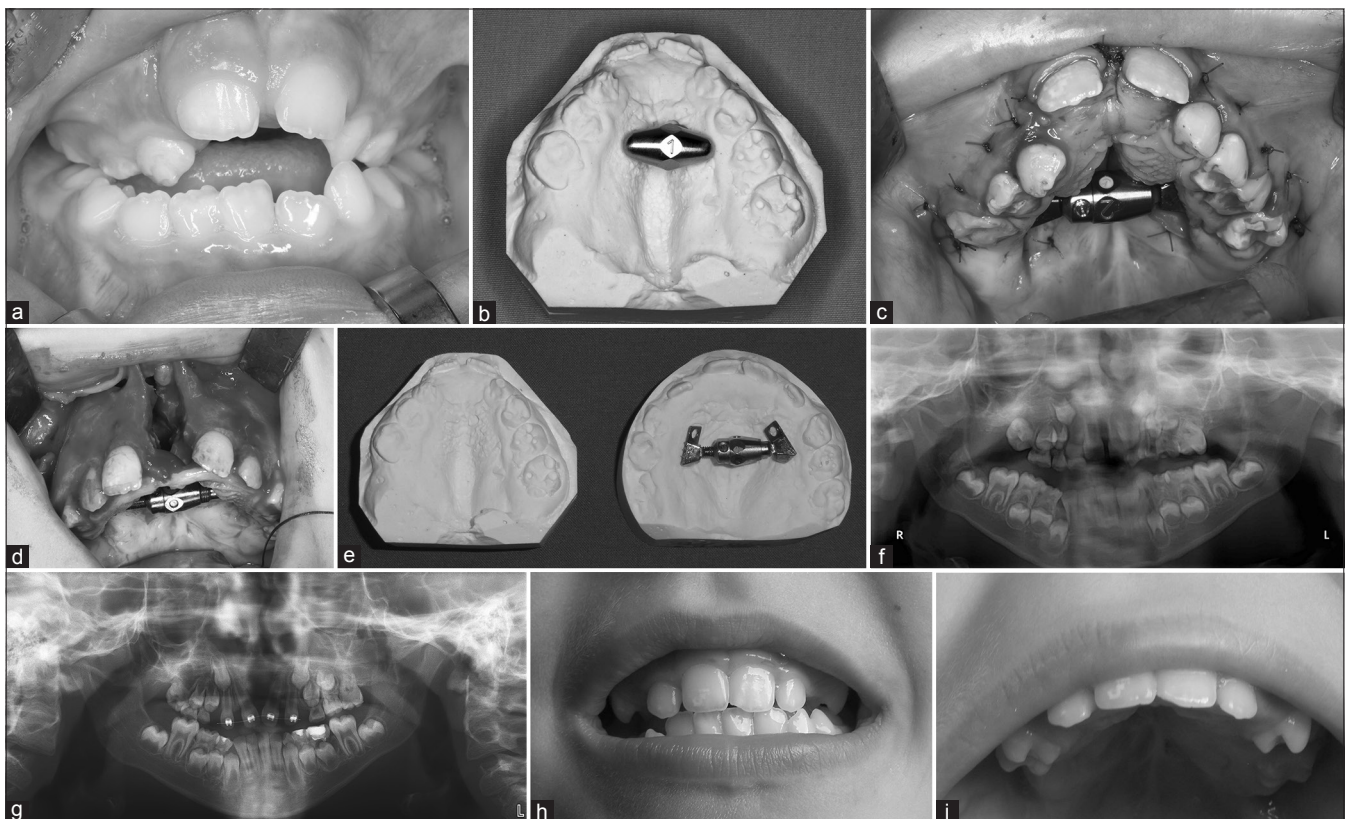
Severe maxillary constriction in a 6-year-old boy affected by Crouzon-preoperative situation (a) selection of an appropriate device according to the individual plaster cast (b) intraoperative situation after insertion of the Surgitec device in May 2011 for the first distraction (c) intraoperative situation during the second distraction 3 months later, the same device is positioned more anterior in order to create additional alveolar crest (d) comparison of plaster casts before and after two stage transpalatal distraction (TPD) (e) panoramic X-rays before (f) and 12 months after (g) TPD demonstrating maxillary expansion—clinical follow up 36 months after pediatric TPD with stable skeletal situations (h and i) additional widening might be required
